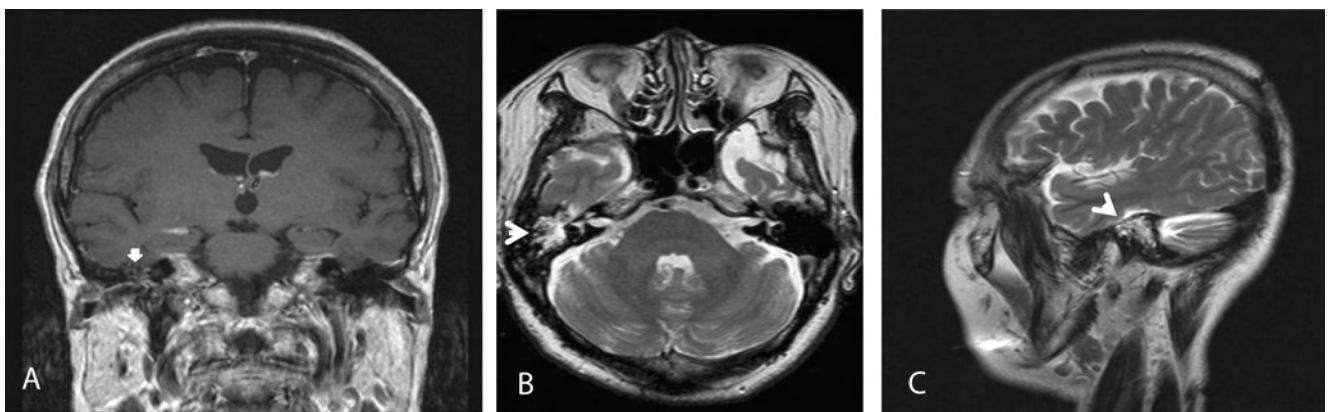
Pre-operative brain MRI. Gd-enhanced T1-weighted coronal image (A) shows no evidence of brain herniation in the epitympanum and isosignal intensity (arrow). Unenhanced T2-weighted axial (B) and sagittal (C) images demonstrate high-signal intensity in the right middle ear and mastoid cavity (arrow head).
